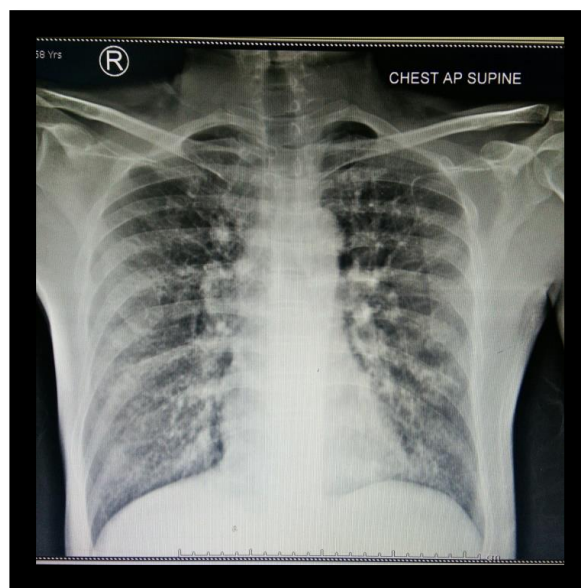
Chest Radiograph of the patient
